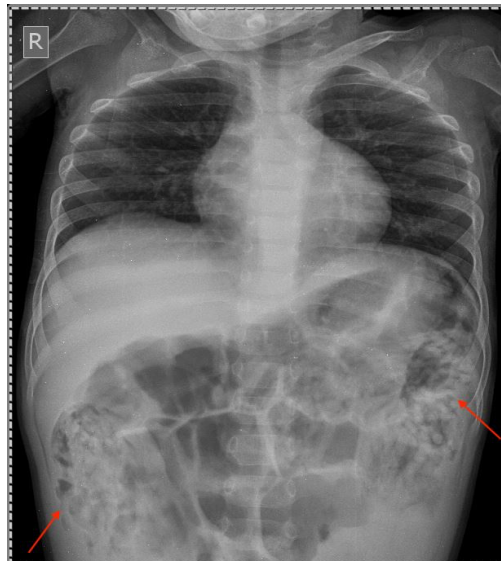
A plain abdominal radiograph of the patient revealed a "cigar bundle" appearance (red arrows).
